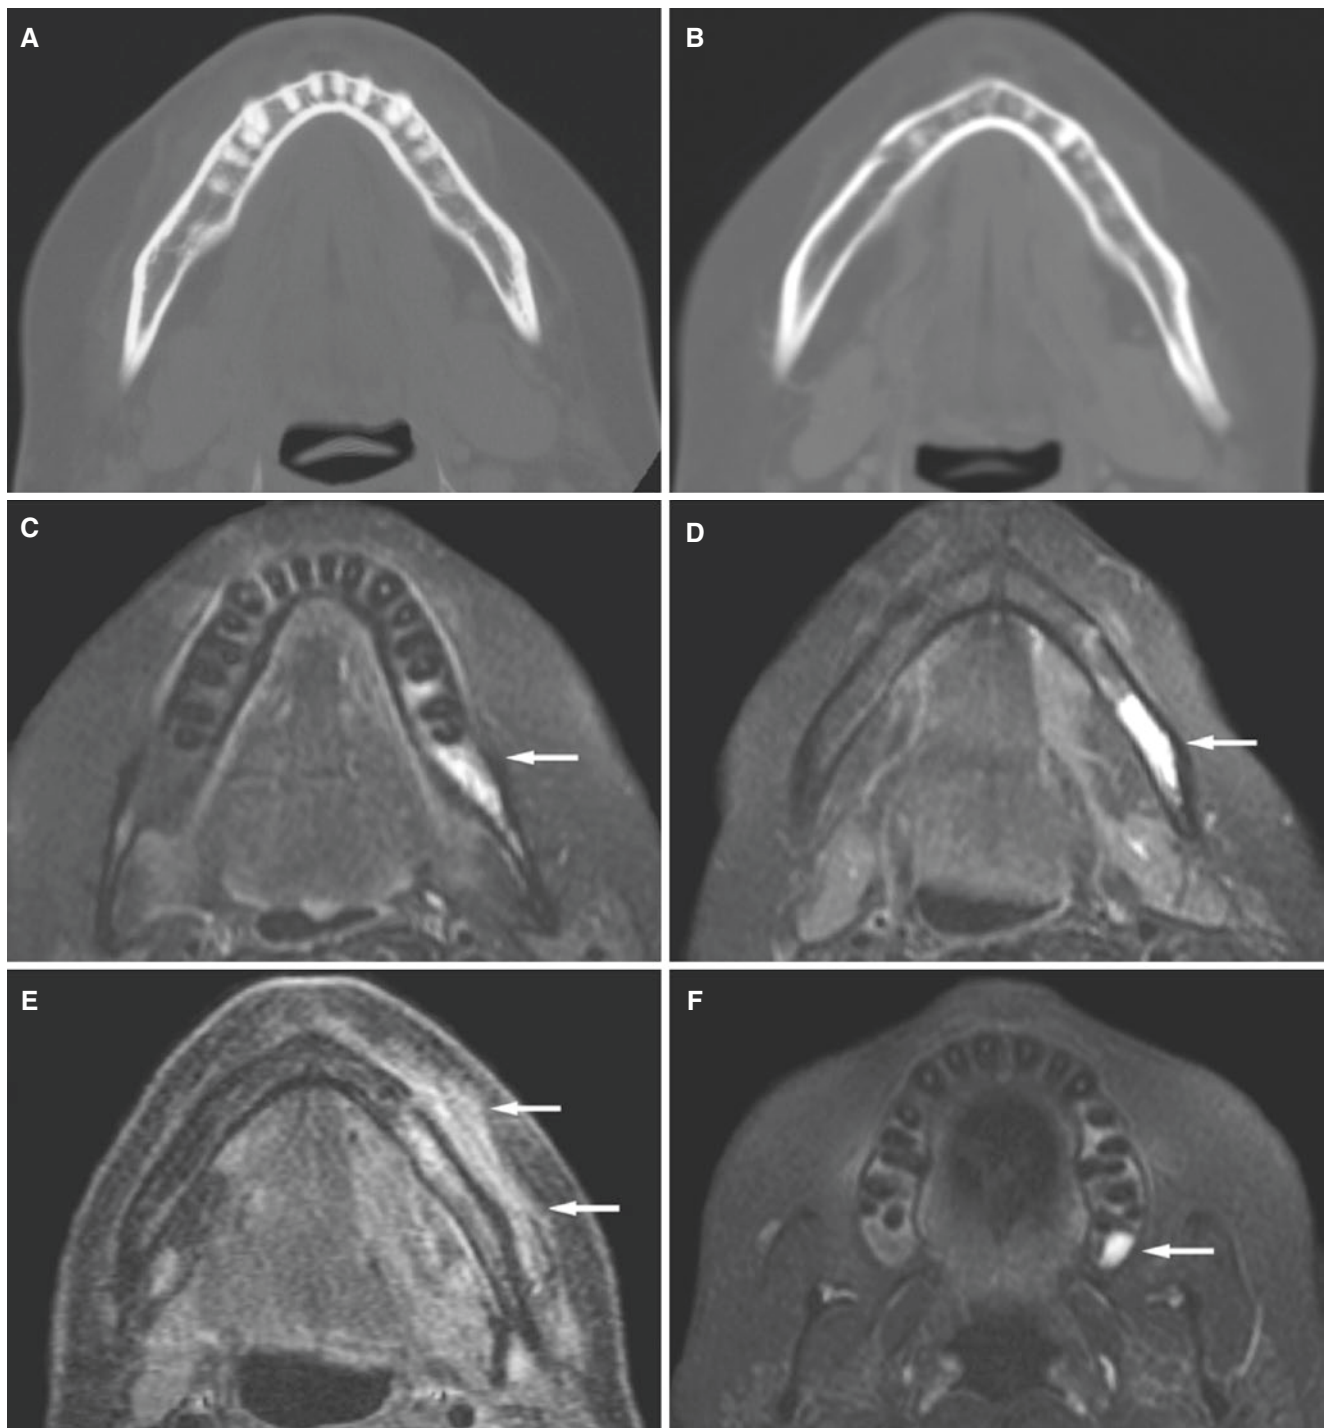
Leukemia, mandible and maxilla; 42-year-old female with numbness and weakness of the left jaw. (A) Axial CT image shows normal bone of tooth-bearing areas. (B) Axial CT image shows normal bone caudad to teeth. (C) Axial T1-weighted fat sat post-Gd MRI shows high signal in bone marrow of tooth-bearing area (*arrow*). (D) Axial
